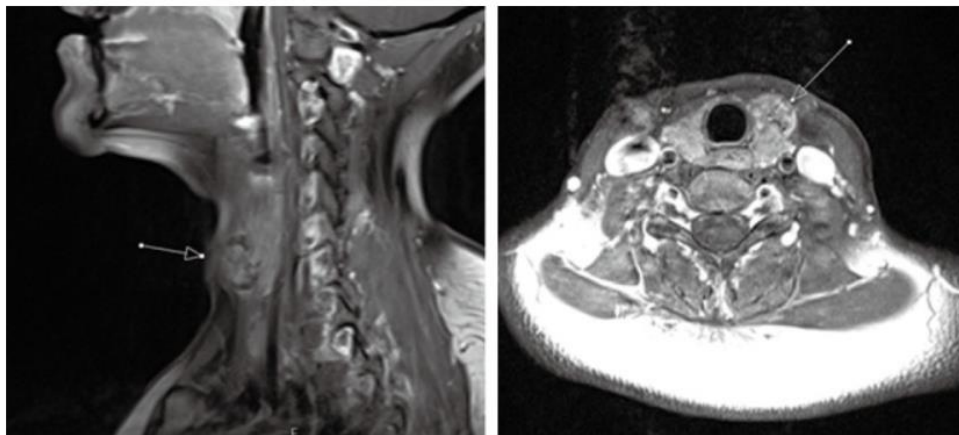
Sagittal (left) and axial (right) T1-post contrast MRI of a 37-year-old female diagnosed with papillary thyroid carcinoma. T1-post-contrast MRI demonstrates heterogeneously enhancing nodule in the anterior aspect of left thyroid lobe (arrows) with well-circumscribed borders without evidence of ipsilateral adenopathy or tracheal invasion.
